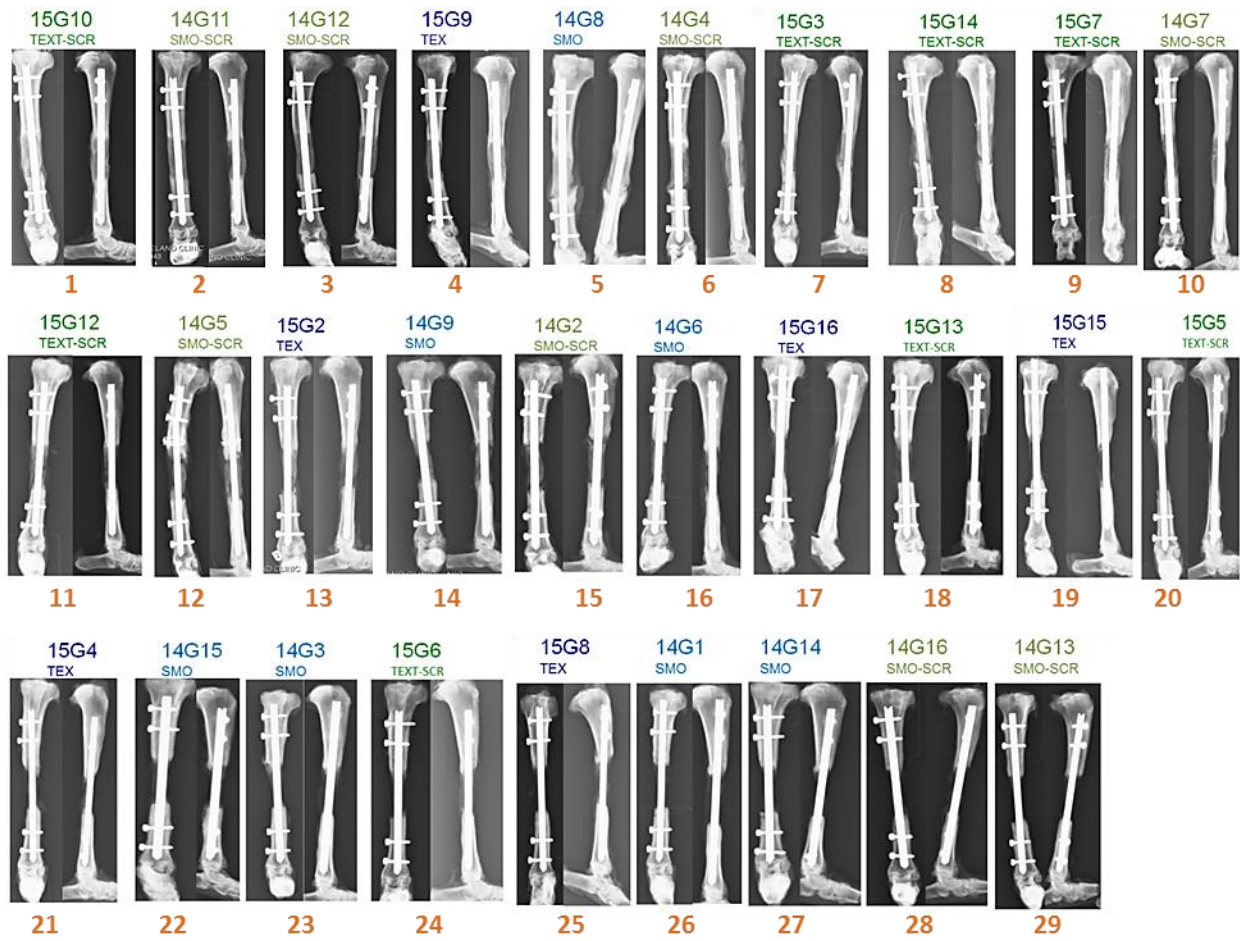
12-week radiograph ranking. Higher rank number indicates greater tibial bone formation (1 = greatest bone healing to 29 = no healing).
